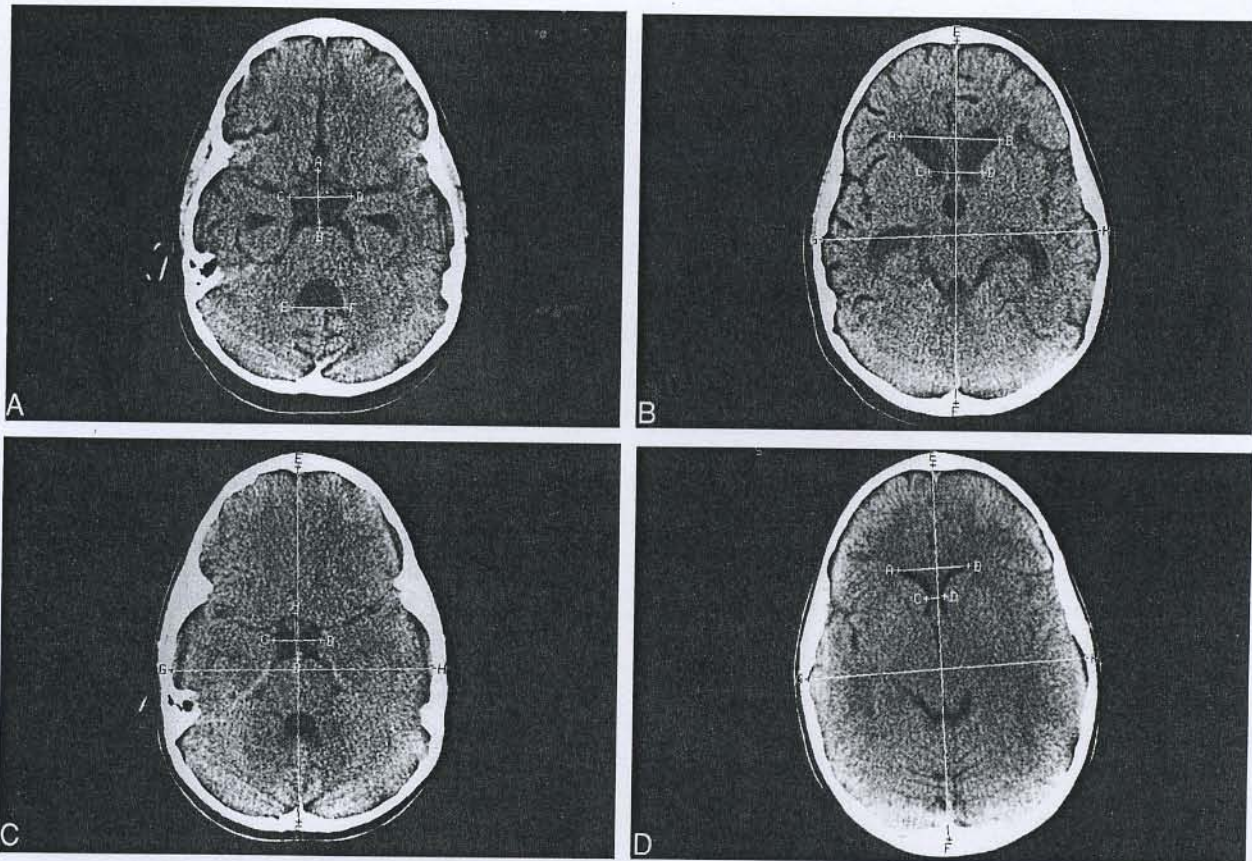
Computed tomography measurements of (A) the anteroposterior [AB] and transverse [CD] diameters of the basal cistern and the width of the fourth ventricle [EF], (B) the anterior horns [AB], and bicaudate nuclei distance [CD] in a 6-year-old boy with acute lymphoblastic leukemia, 18 months after the onset of therapy. (C) and (D) show corresponding reference measurements in the computed tomography examination of the same child performed before the onset of treatment.
